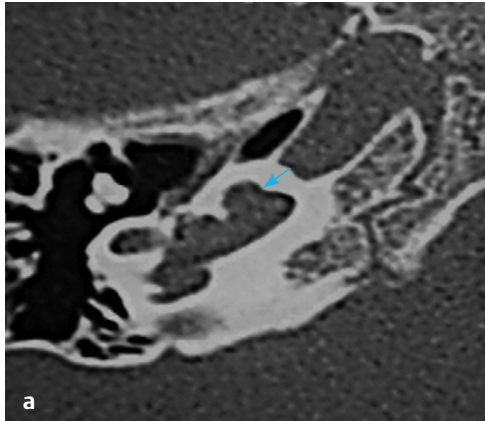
(a, b) HRCT temporal bone, bone window and (c) MRI CISS sequence, axial sections show IP1. Cochlea (blue arrow) without modiolus and interscalar septum, and bright signal on MRI on left side indicates CSF in middle ear (pink arrow) and going into the eustachian tube.
